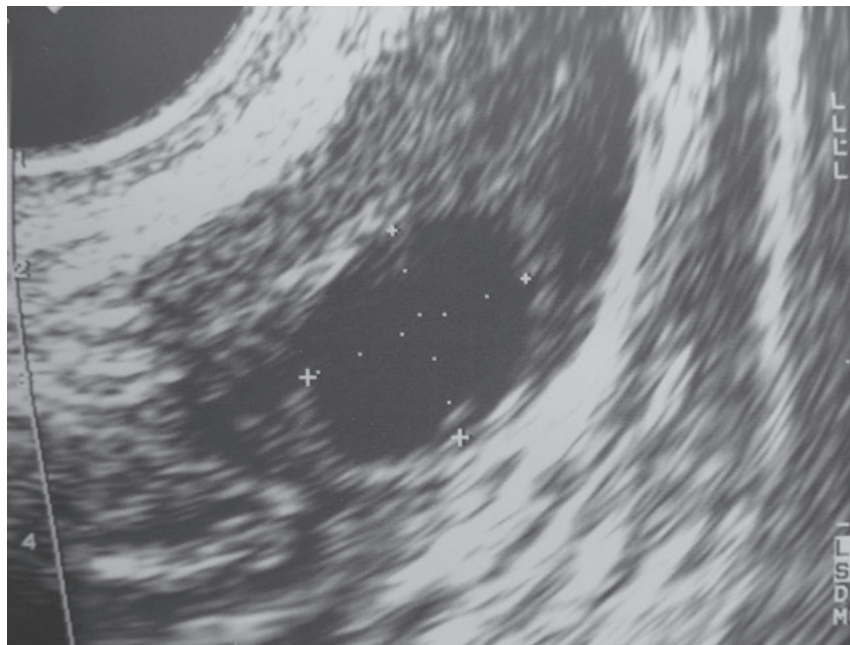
Ultrasonographic Appearance of a Functional Cyst
